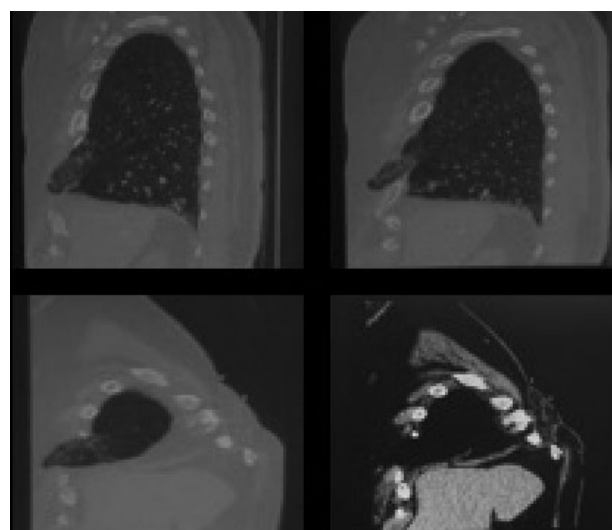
Sagittal CT views of middle lobe hernia.
